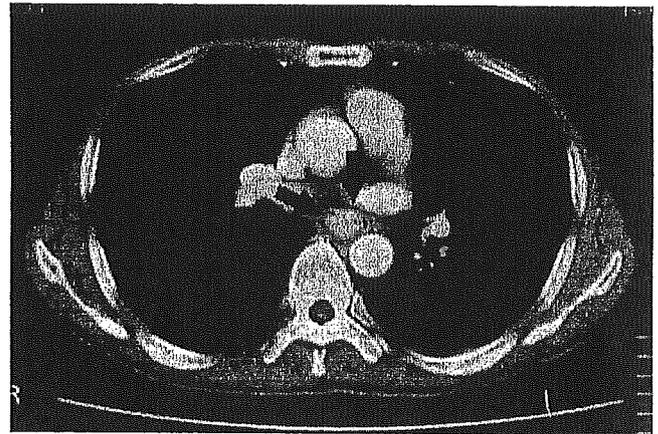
CT of the chest showed enhancement of the esophageal tumor (arrows).
